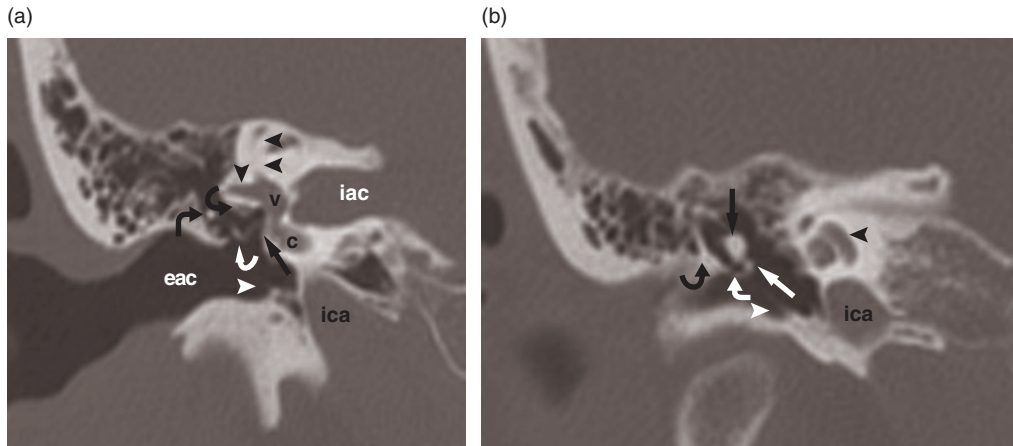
High-resolution CT of the right petrous bone: coronal images. (a) External auditory canal (eac), tympanic membrane (white arrowhead), malleus head (angled arrow), incus (curved white arrow), stapes (straight arrow), facial nerve (curved black arrow), cochlea (c), vestibule (v), lateral semicircular canal (arrowhead), superior semicircular canal (double arrowhead), internal auditory canal (iac), internal carotid artery (ica); (b) Tympanic membrane (white arrowhead), Prussak pouch (angled arrow), lateral tympanic wall (curved arrow), malleus head (black straight arrow), malleus short process (white straight arrow), cochlea (black arrowhead), internal carotid artery (ica) (reproduced from Calzolari F., 2006,⁶ with permission of Omega Edizioni).
